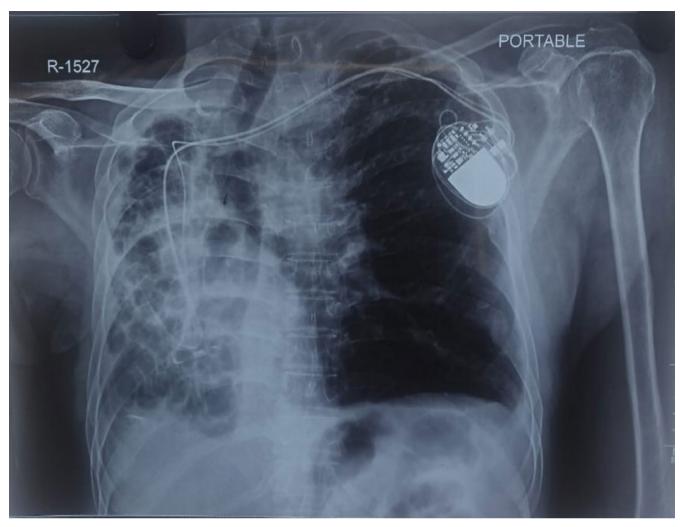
Post procedure chest X-Ray of the patient showing dextroposed heart with pacemaker in situ.
